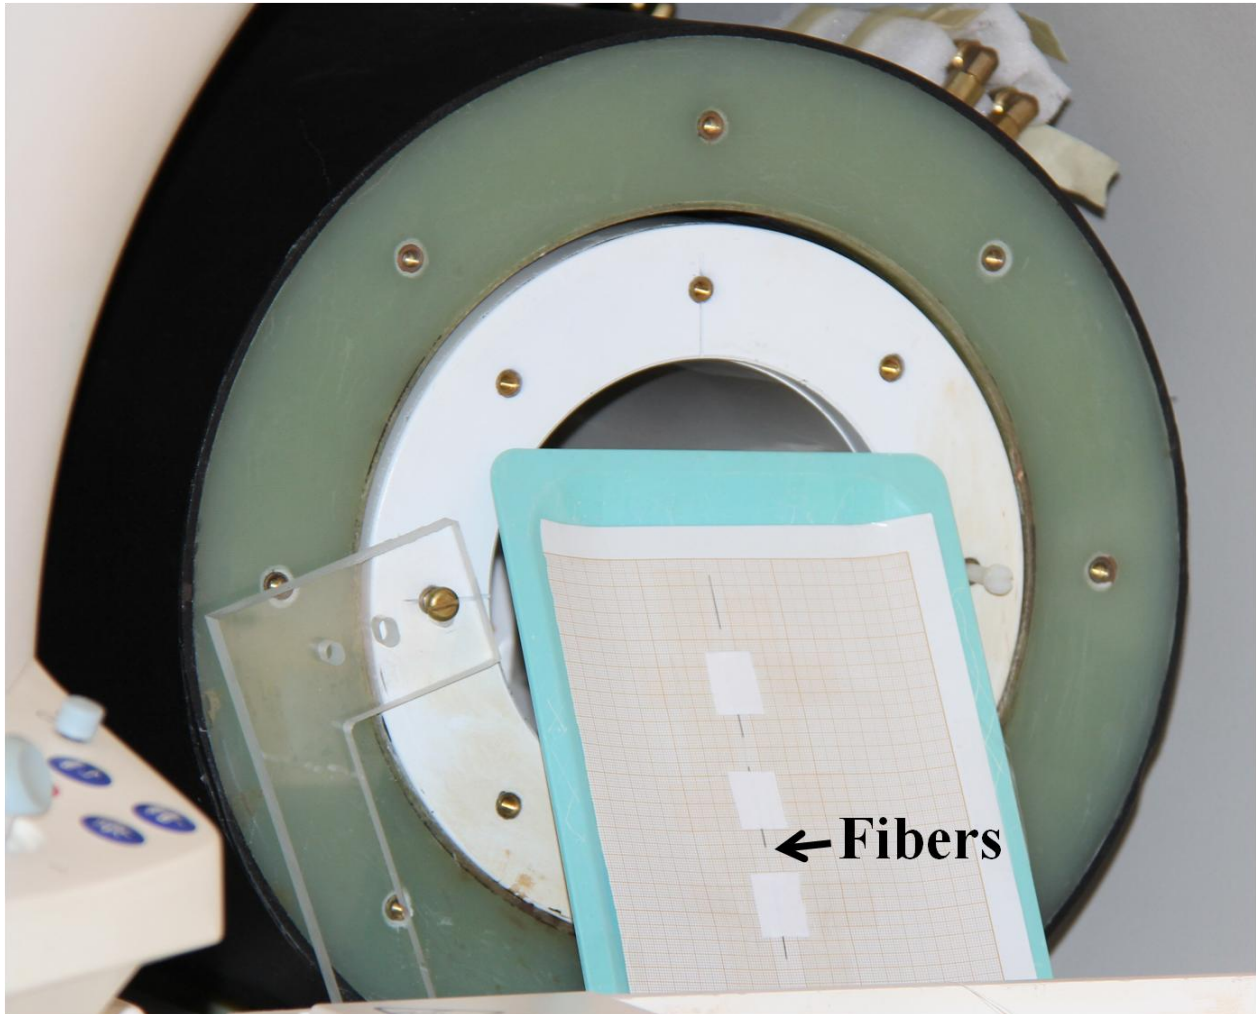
Image shows the fibers placed inside the bore of a 1.5T MRI scanner.
